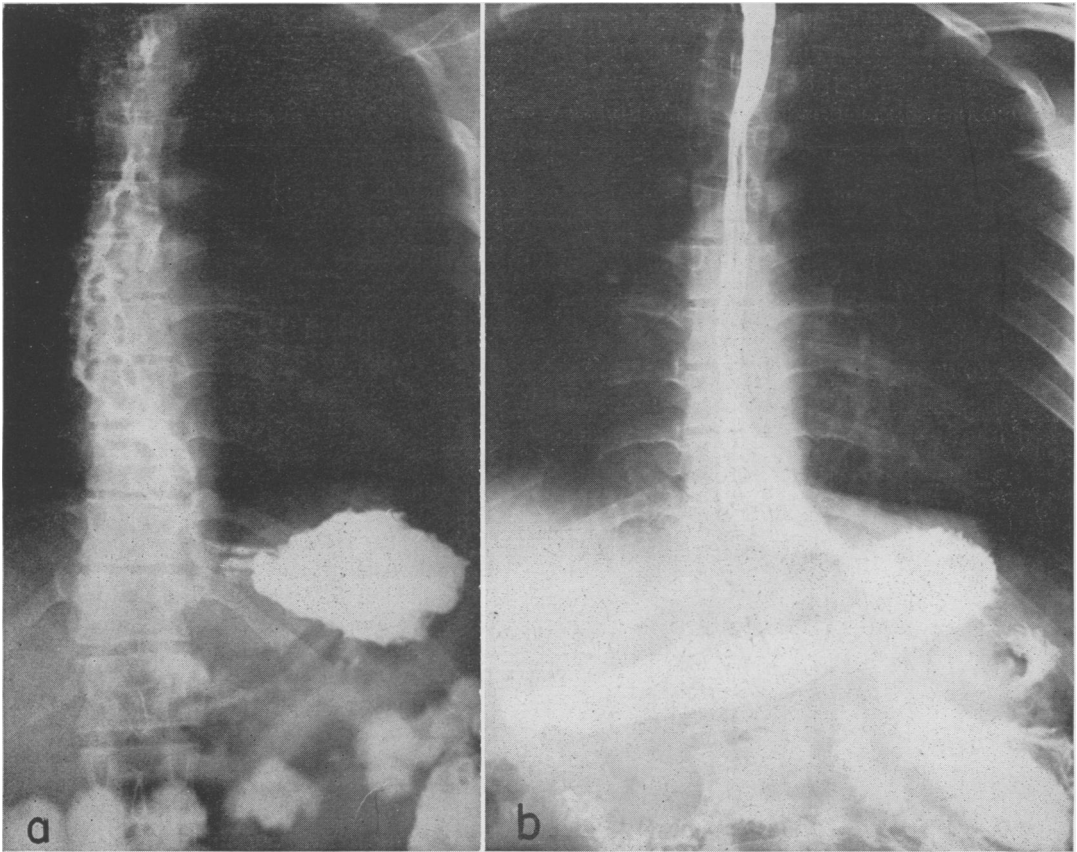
Roentgenograms of the esophagus of D.S. (Case 2) following barium swallow. (a) Before the shunt operation. The varices, which are numerous and very large, can be seen to extend up to the patient's neck. (b) One year after venous shunt, the esophagus is smooth and straight. Except for a small questionable area near the diaphragm, all radiologic evidence of varicosities has disappeared. No bleeding has taken place for two years.
